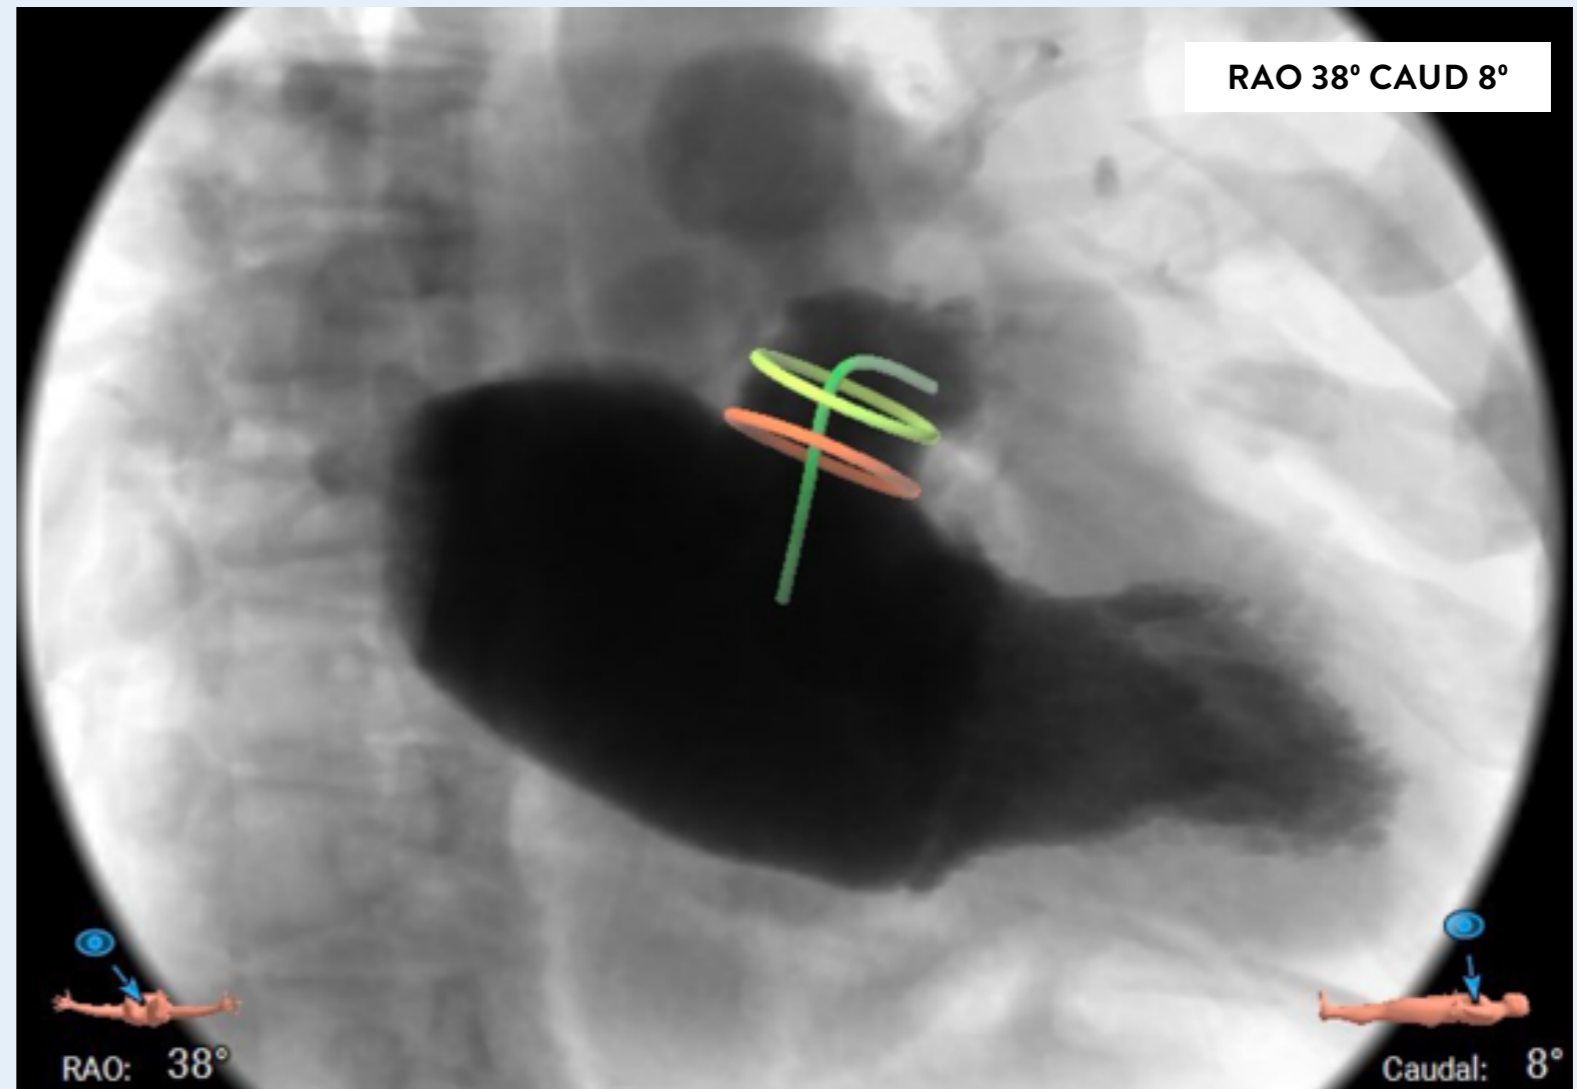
Cardiac CT analysis to determine the optimal implant angle for LAA closure. CT, computed tomography; LA, left atrium; LAA, left atrial appendage.
